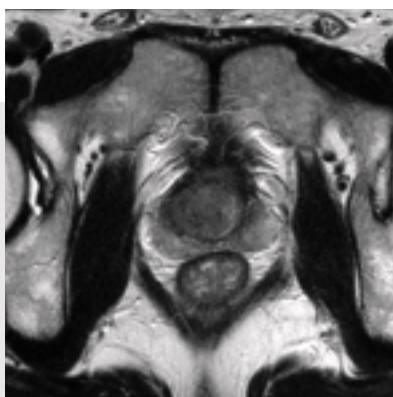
T2-weighted image
